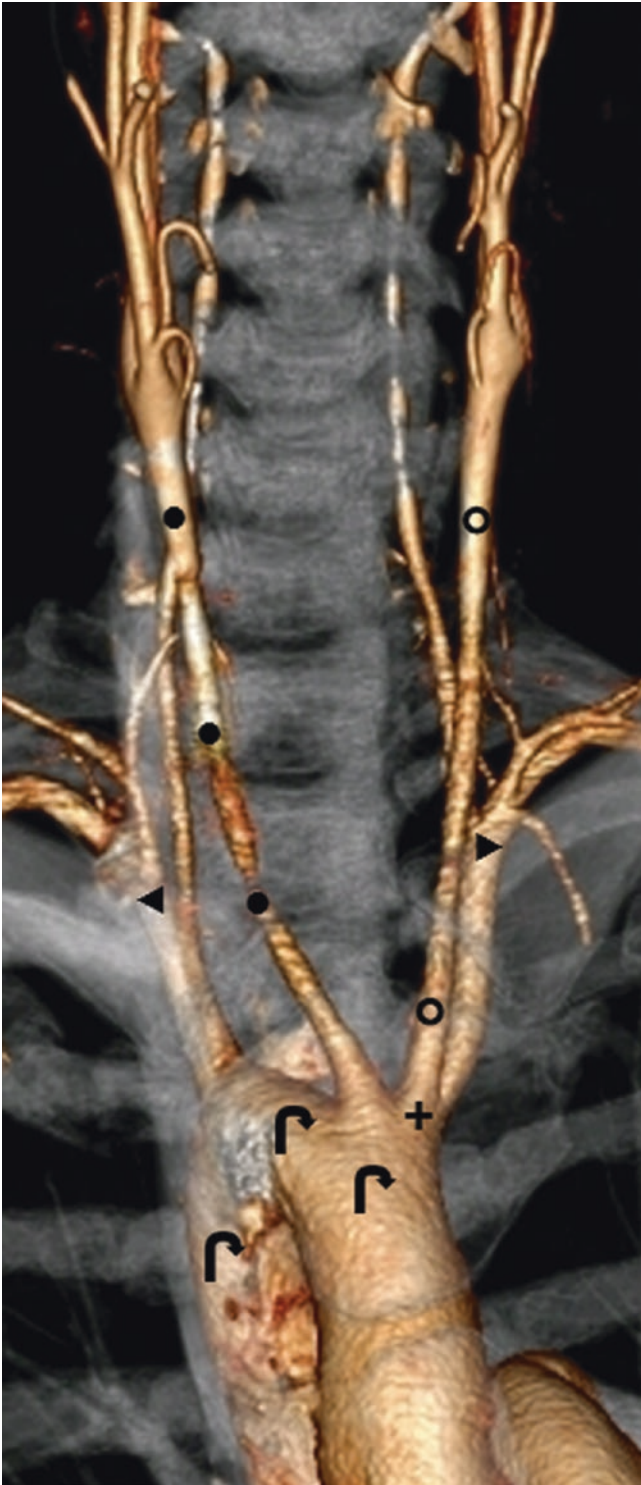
36-year-old with a “mirror-image” right-sided arch on a 3D VR CTA (AP view). *Aortic Arch* (curved arrows); *IA* Innominate Artery (+); *LCCA* Left Common Carotid Artery (○); *LSCLA* Left Subclavian Artery (▶); *RCCA* Right Common Carotid Artery (●); *RSCLA* Right Subclavian Artery (◀)
